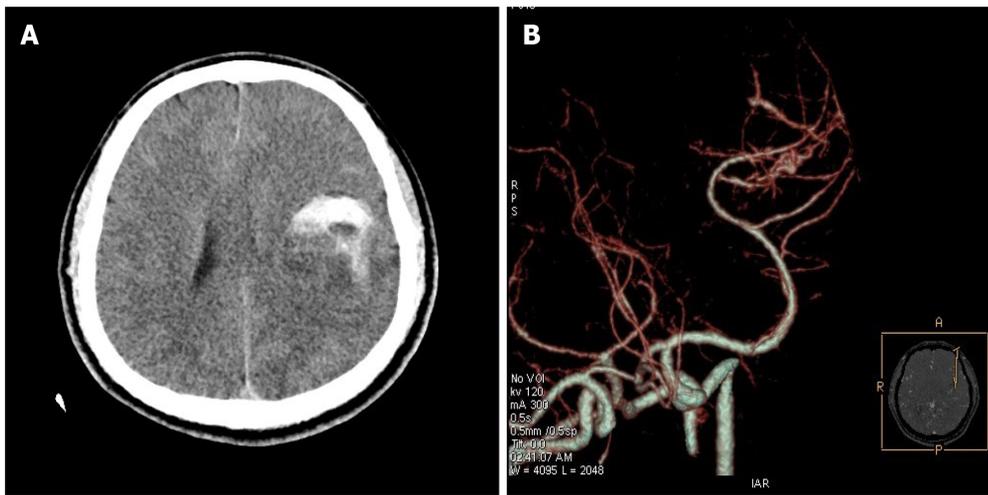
Preoperative computed tomography and computed tomography angiography. A: Computed tomography (CT) indicated a round space on the left with high-density shadows, suggesting tumor with hemorrhage; B: CT angiography indicated the possibility of arteriovenous malformation of the left middle cerebral artery.
